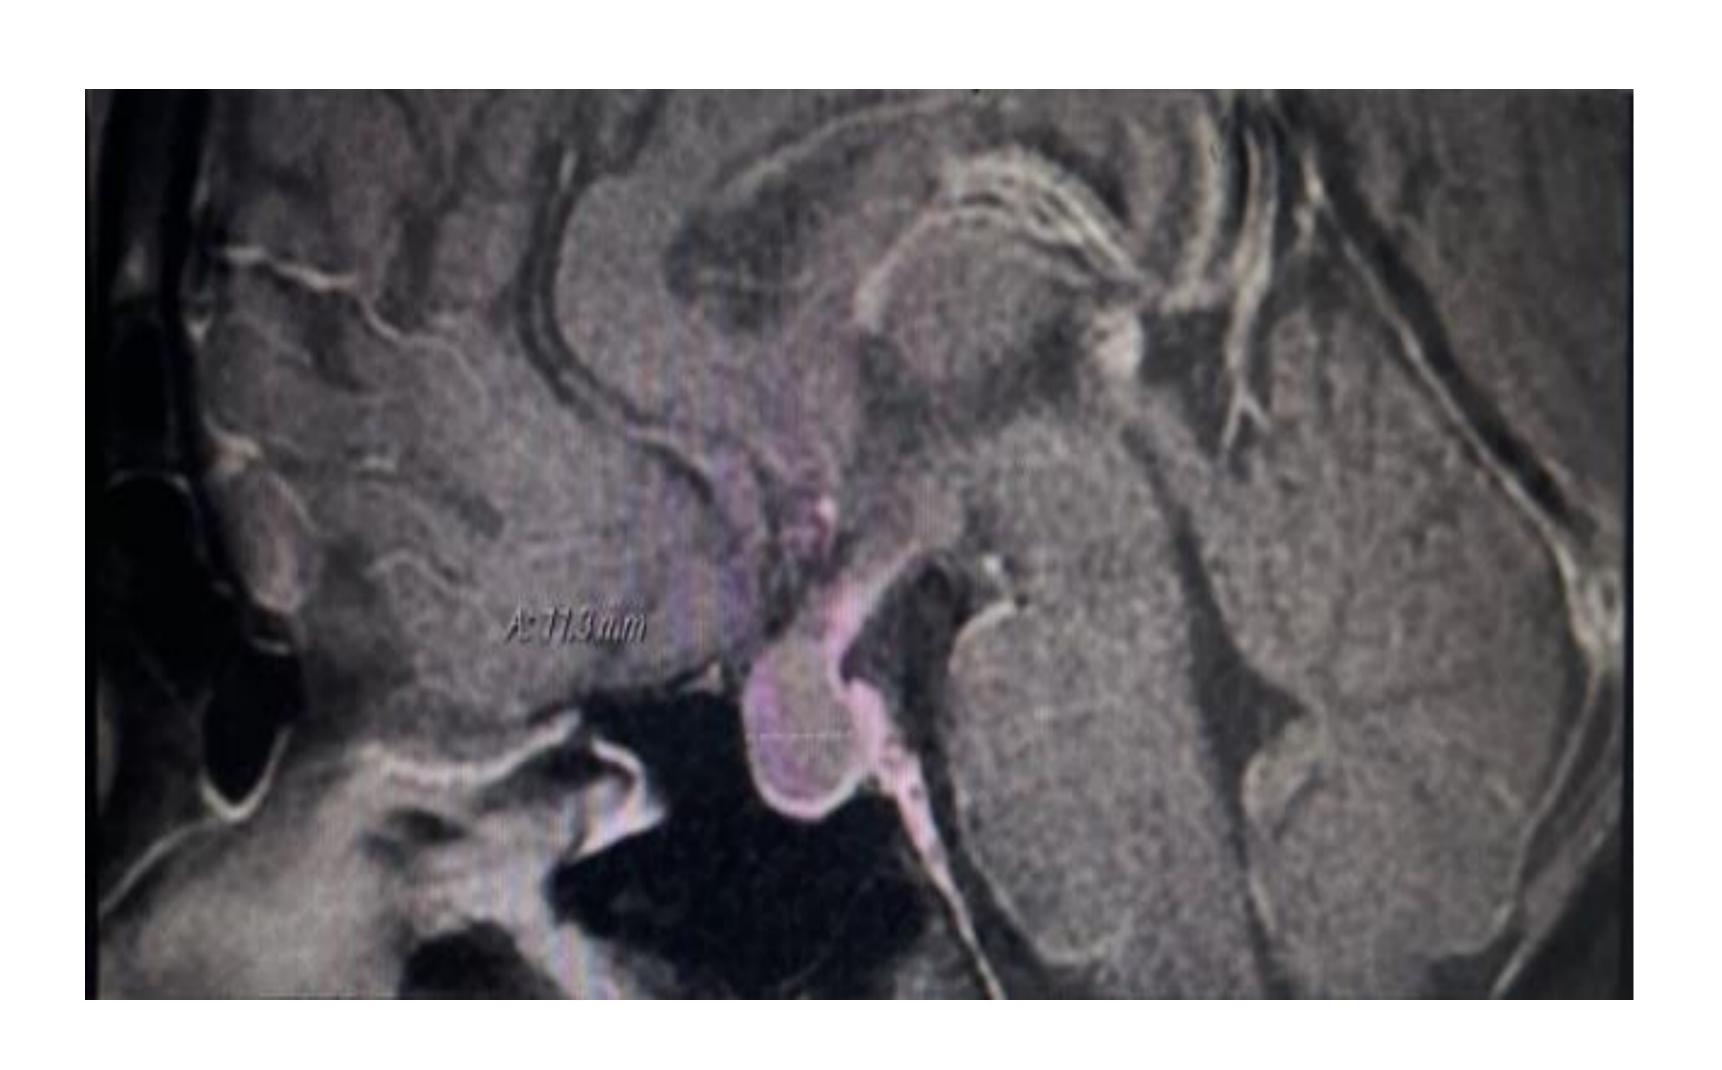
Sagittal view of brain MRI shows measurement at 11.3mm, classifying adenoma as a Macroadenoma.
